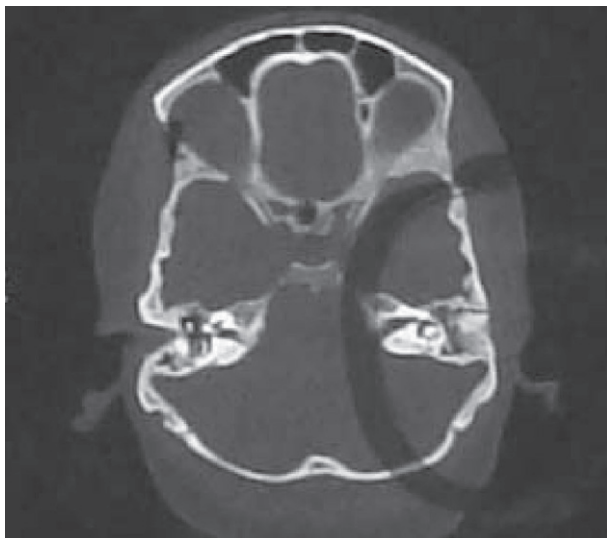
High resolution CT of skull base showing fracture through the left petrous
